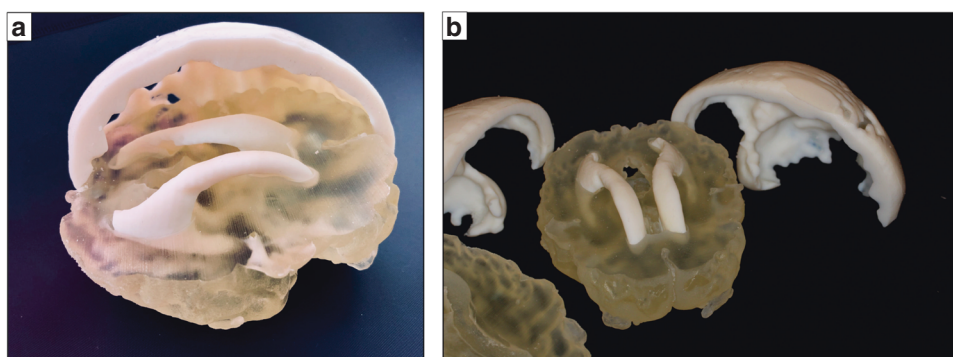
Anatomic reconstruction and 3D printed model of patient H1. Multimodality imaging-based 3D printed model of the neonatal head including the skull, brain, and lateral ventricles derived from 3D MRI and 3D ultrasound. a Assembled and b non-assembled.
